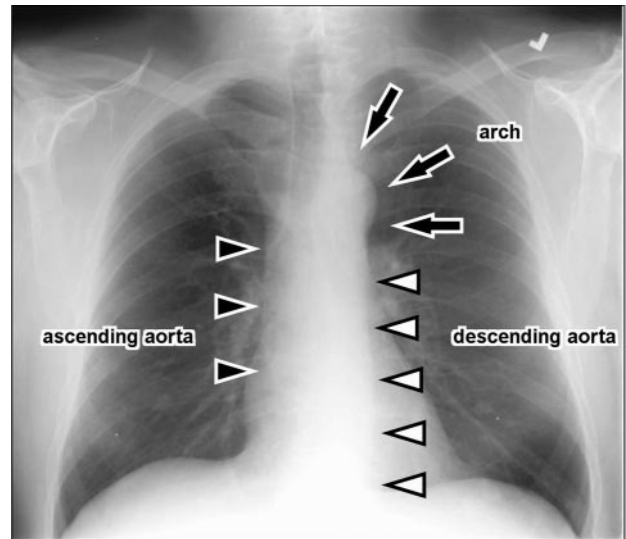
Chest x-ray of a normal thoracic aorta. Arrows indicate arch, and arrowheads show ascending and descending aorta.
